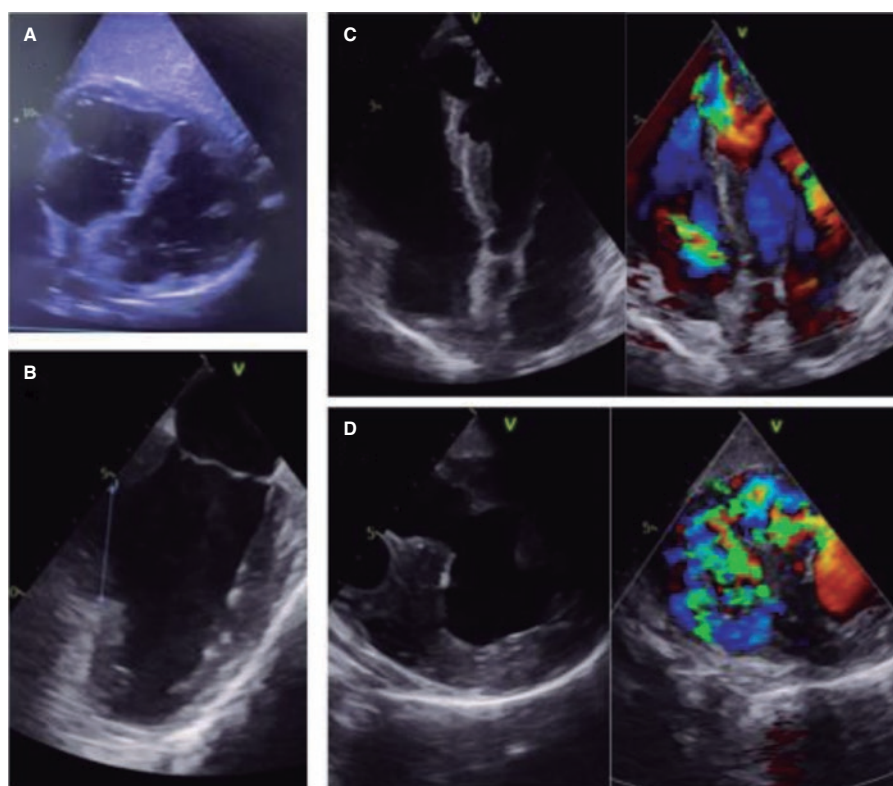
Large inferoseptal ventricular septal defect up to the apical segments as seen on the transthoracic echocardiography (A) with a 50 mm maximum diameter as seen on the transesophageal echocardiography. (B) The long (C) and short (D) axes seen on the transesophageal echocardiography reveal the presence of a non-restrictive left-to-right shunt.
